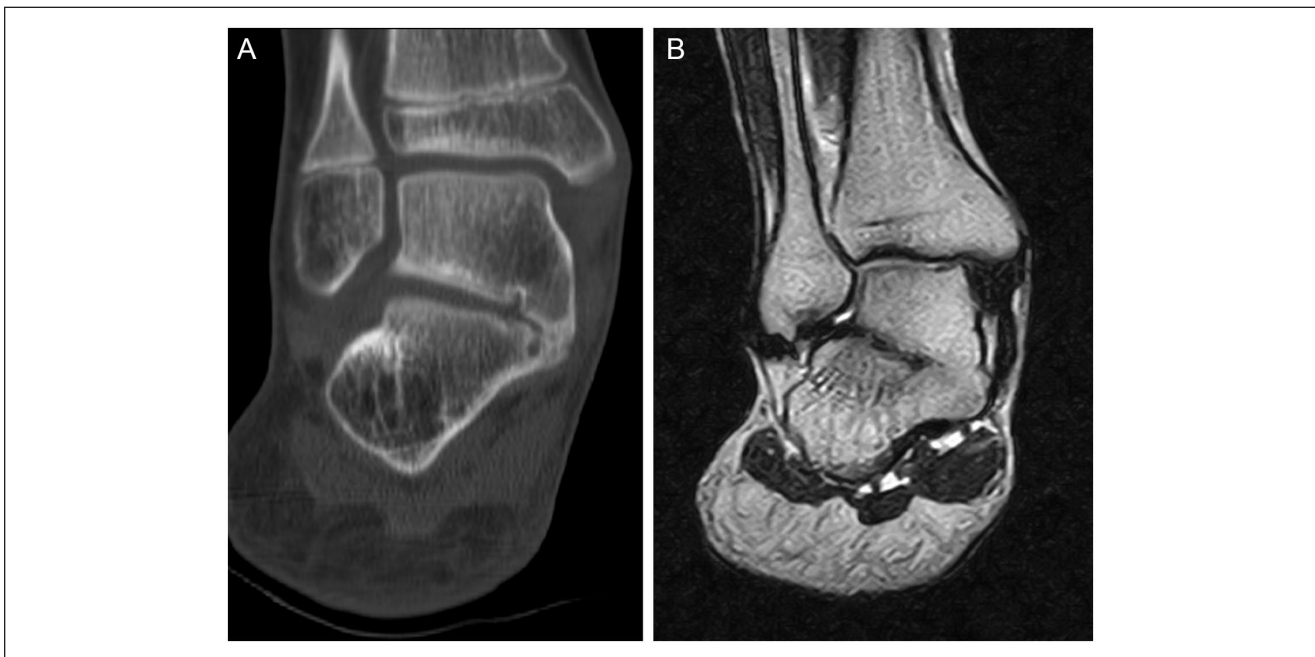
(A) Coronal slice computed tomography scan of the hindfoot in a 12-year-old patient affected by talocalcaneal coalition (TCC) and valgus deformity. (B) For comparison, magnetic resonance imaging slice of an untreated similar type of TCC in a 32-year-old patient with a rigid valgus deformity of the hindfoot complaining of pain laterally for the calcaneofibular impingement; see also arthritis of the subtalar and the ankle joints.
